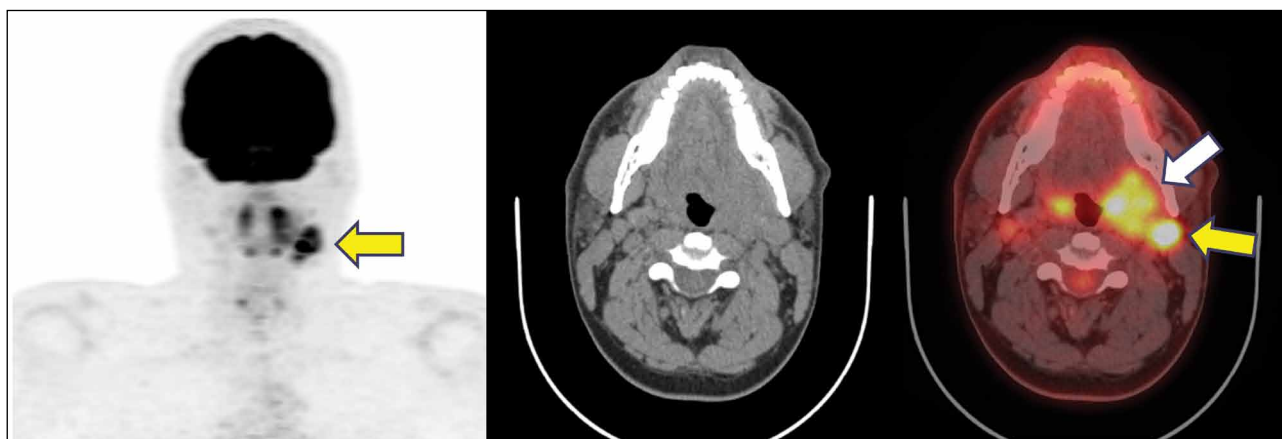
Oropharyngeal cancer. Case of oropharyngeal cancer with hypermetabolic enlargement of the left palatine tonsil (white arrow) obliterating the adjacent parapharyngeal space. There are FDG-avid, disease-involved ipsilateral jugular nodes (yellow arrow). Oropharyngeal cancer is the most common head-neck cancer in the western world, often arising in the tongue base or in the palatine tonsils. It, often, shows a predictable pattern of nodal spread from superior to inferior, first involving the upper jugular chain and then the middle and lower nodes.
